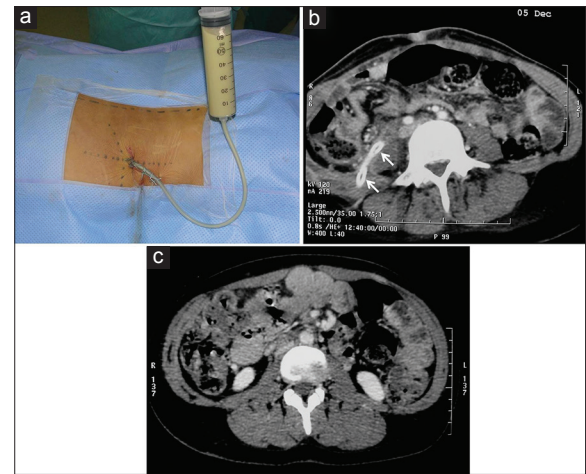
Operative view demonstrating posterior percutaneous drainage of the purulent collection above the right iliac crest (a). Follow-up abdominal CT scan 2 days after drainage of the abscess. Note the placement of the percutaneous drain (arrows) and the near complete resolution of the retroperitoneal collection (b). A follow-up axial abdominal CT scan with contrast injection 6 months postoperatively showing the absence of recurrent abscess (c)
